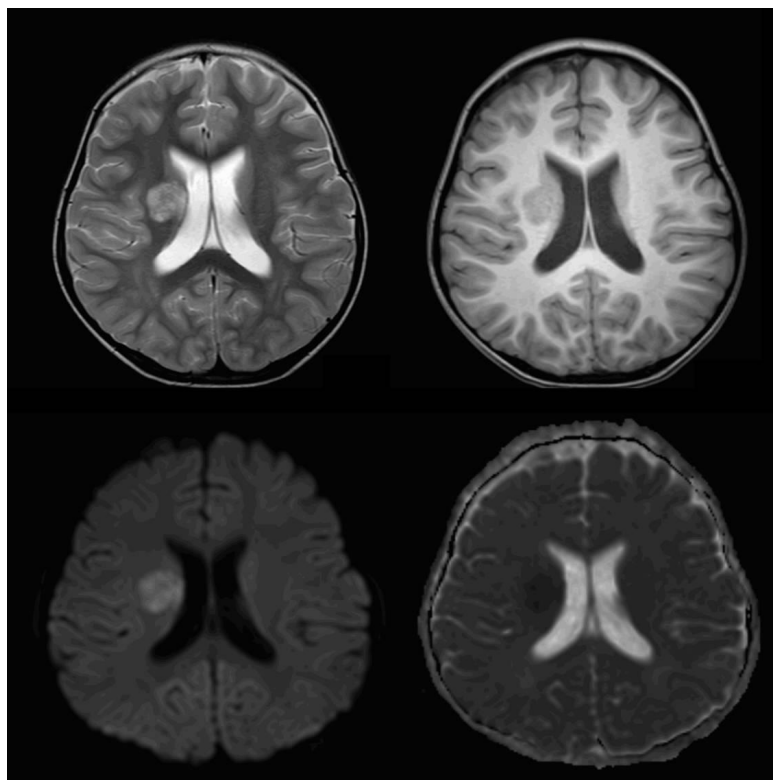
Magnetic resonance imaging (MRI) was performed on a 3T MRI scanner (Achieva 3T; Philips Medical System). MRI images showed a round lesion involving the right basal ganglia, which was hyperintense on T2-weighted images (top left image) and hypointense on T1-weighted images (top right image), with diffusion restriction (bottom left image) and low apparent diffusion coefficient values (bottom right image), indicating acute infarction in the area of the right lenticulostriate arteries.
